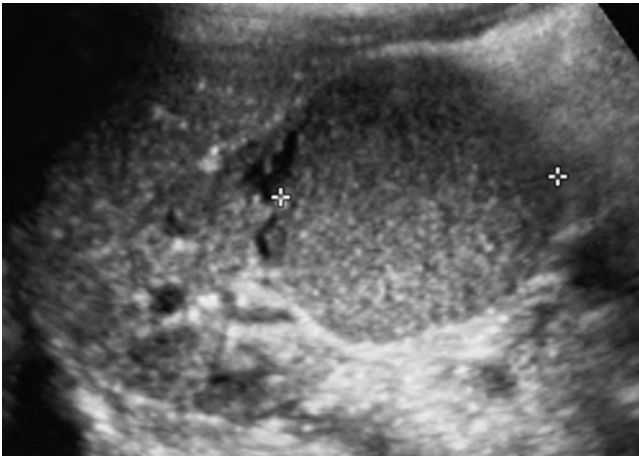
Nephroblastoma (Wilms tumor) detected by sonography.
